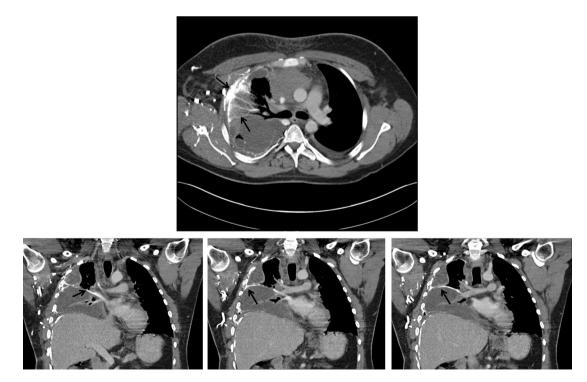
Transverse (top) and coronal (bottom) views of CT scan images obtained with contrast administered through a right antecubital intravenous access, showing pleural enhancement (top, arrows) and bridging veins connecting intercostal and new chest wall collaterals draining into the pulmonary vein (bottom, arrows).
